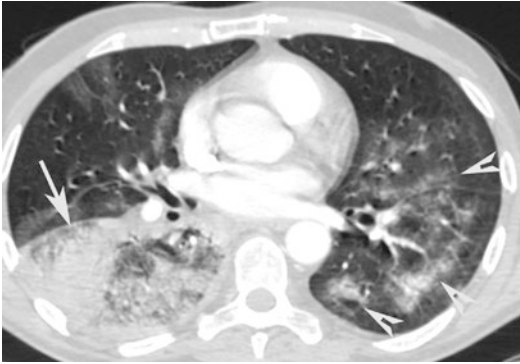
Bronchopneumonia. CT axial scan demonstrates multiple confluent areas of consolidation (*arrow*) of the right lower lobe and patchy lobular areas of consolidation of the left lower lobe (*arrow tips*)
